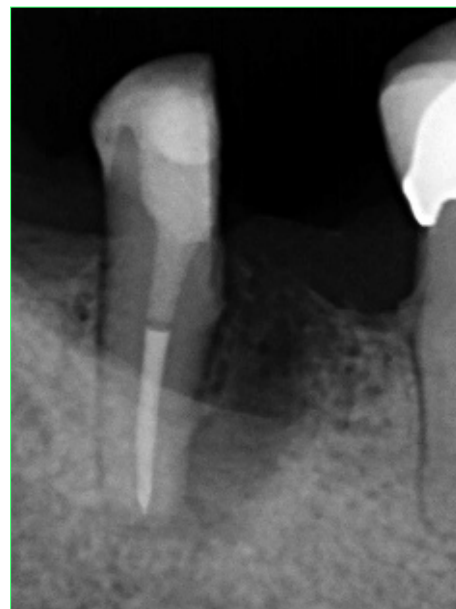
Corresponding radiograph.
